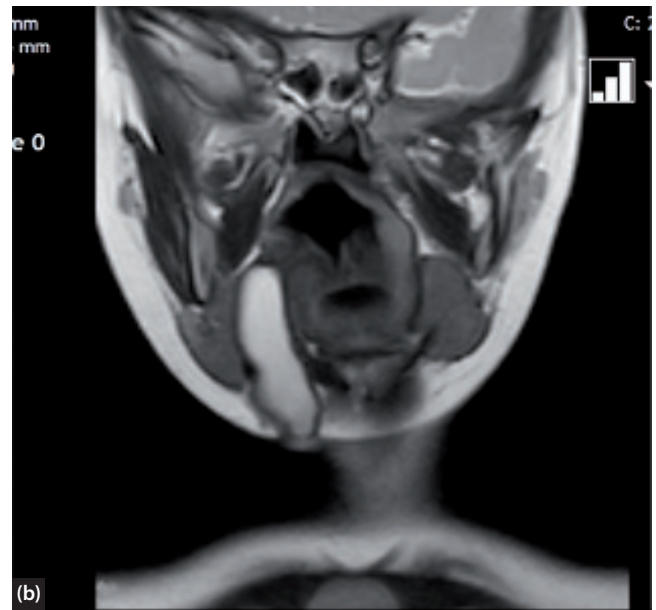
(a) Pre-operative appearance of a type IV second branchial cleft cyst/sinus, (b) with coronal and (c) axial T2-weighted imaging.
